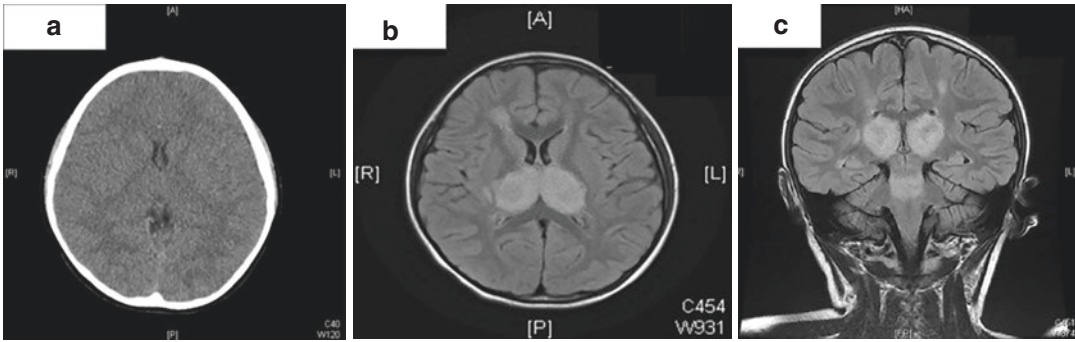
Brain computerized tomography (CT) on admission showed no specific findings (a). Brain magnetic resonance imaging (MRI) on day 3 after admission showed
